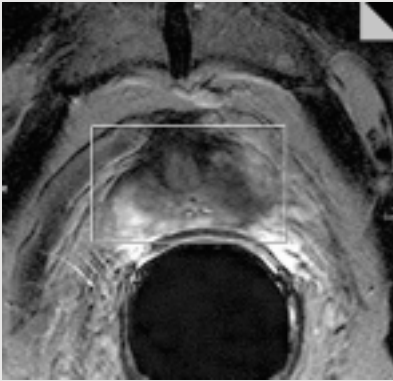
Axial T2-weighted image through the base of the prostate. The white box is the volume of interest, or the PRESS box, of the 3D MRSI measurement.
